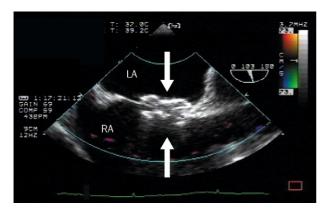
Transoesophageal echocardiographical image of a secundum atrial septal defect after closure with Amplatzer device
